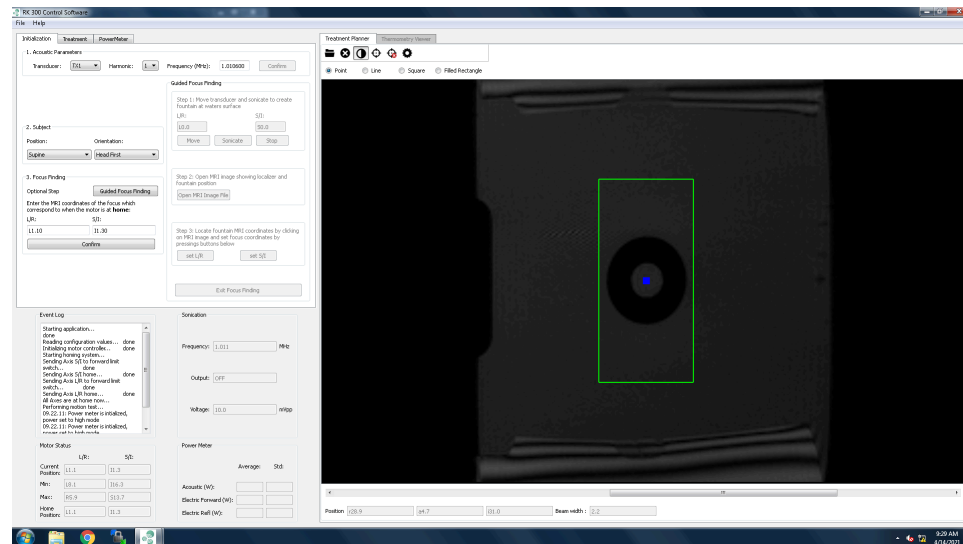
Loaded MRI scan to register the focus
